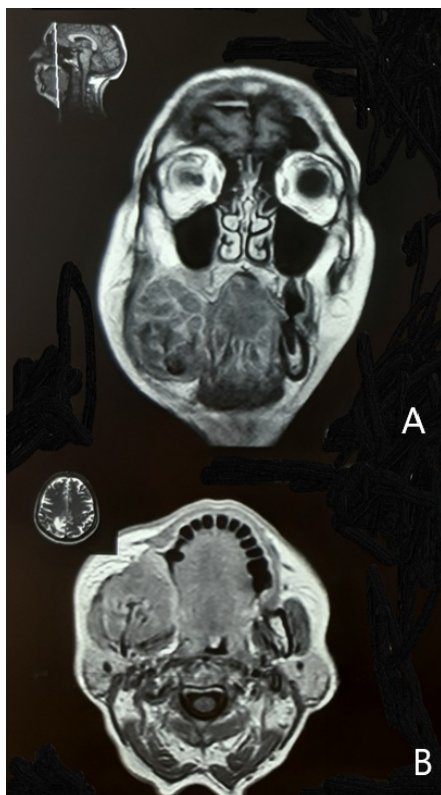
MRI of the head, showing perimandibular metastasis in the coronal (A) and axial (B) plane
